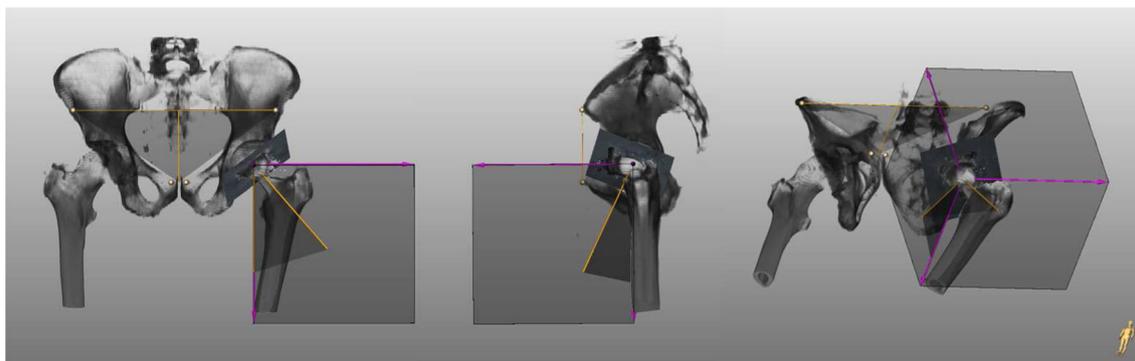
The software developed by MeVis for measuring inclination and anteversion from a postoperative CT scan. The surface model was interactively segmented using the image-processing software
